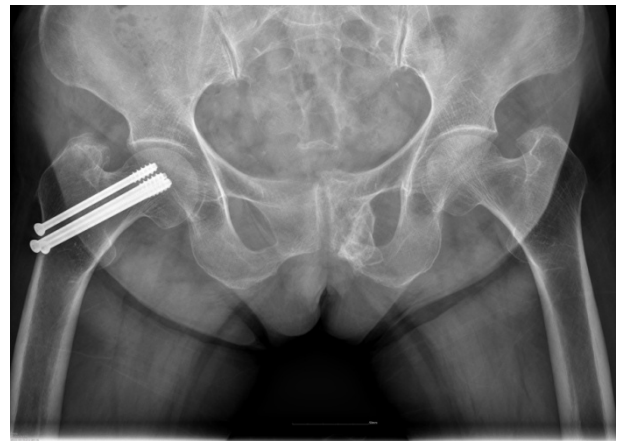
Radiograph at 4 months after the operation shows union state without any complications.
